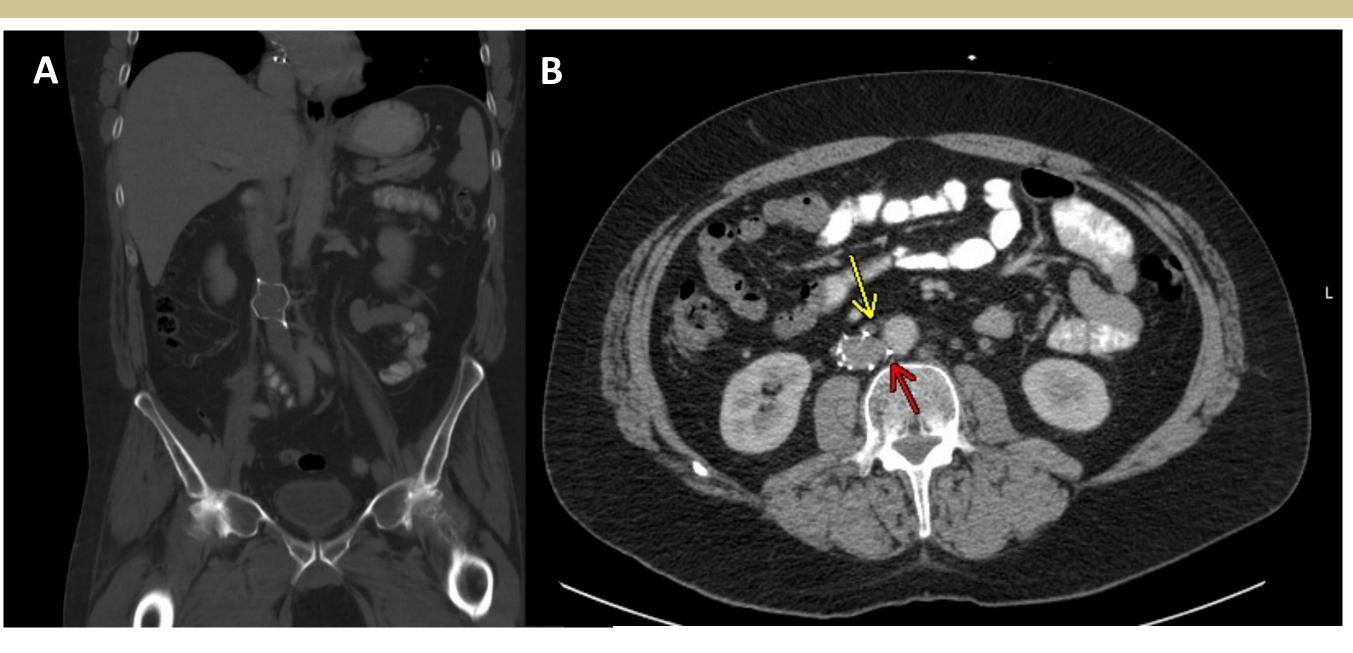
Initial (A) coronal and (B) axial CT showing tilted and embedded OptEase filter. Note proximity of the right gonadal (yellow arrow) and L3 lumbar (red arrow) arteries to the penetrated filter struts.
